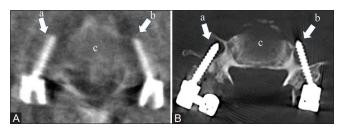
Intra-operative (A) and post-operative (B) 3-D CT showing that the two tips of right (a) and left (b) cervical screws are within the bilateral transverse foramens of the sixth cervical vertebra (c)
